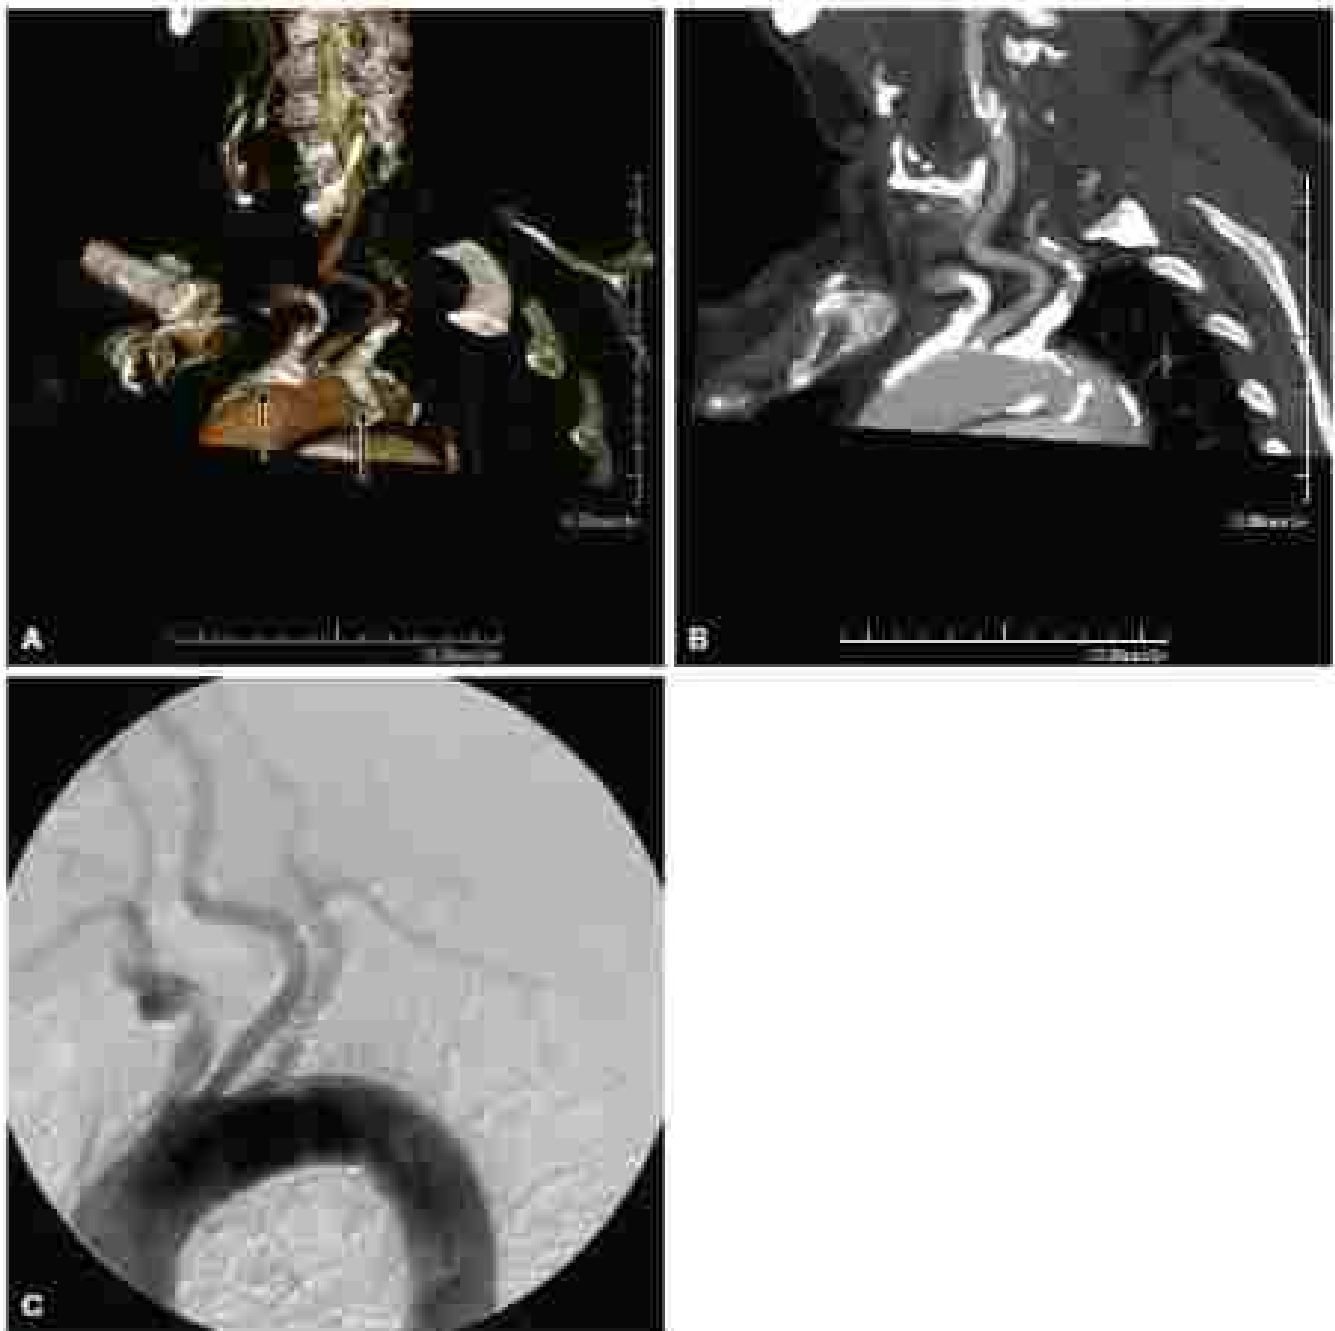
(A) Coronal computed tomographic (CT) scan demonstrating aortic arch involving the origins of the innominate and left subclavian arteries (arrows). (B) Maximum intensity projection image of the same patient reconstructed from the CT scan. (C) Arteriogram of the same patient. Note the extensive calcification at the origins of the innominate and proximal left subclavian arteries. (From Cavalcanti, *et al*, *Journal of Vascular Medicine and Biology*, 2011.)
